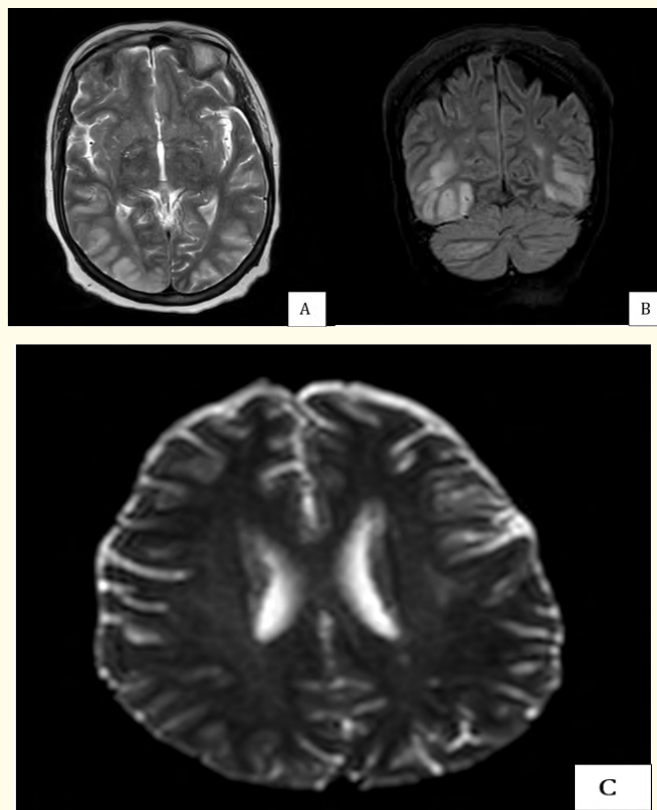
A- Axial T2-weighted MRI shows bilateral and symmetrical hyperintensities in the parieto-occipital lobes, consistent with vasogenic edema. B- Coronal FLAIR MRI demonstrates bilateral hyperintense signals in the parieto-occipital regions, consistent with vasogenic edema. C- Diffusion-weighted imaging (DWI) shows no evidence of restricted diffusion, supporting the diagnosis of vasogenic rather than cytotoxic edema.
